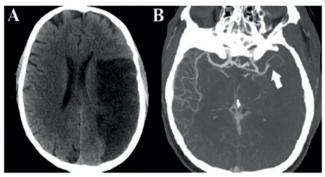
A. Non-contrast CT brain in a 57-year-old male with COVID-19 shows hypoattenuation in the left MCA territory. B. CT angiography in the same patient demonstrates occlusion of the left M2 branch (arrow). There is no distal reformation. Figure reproduced with permission from Sayan Manna et al. (2020); copyright 2020 RSNA doi.org/10.1148/ryct.2020200210
